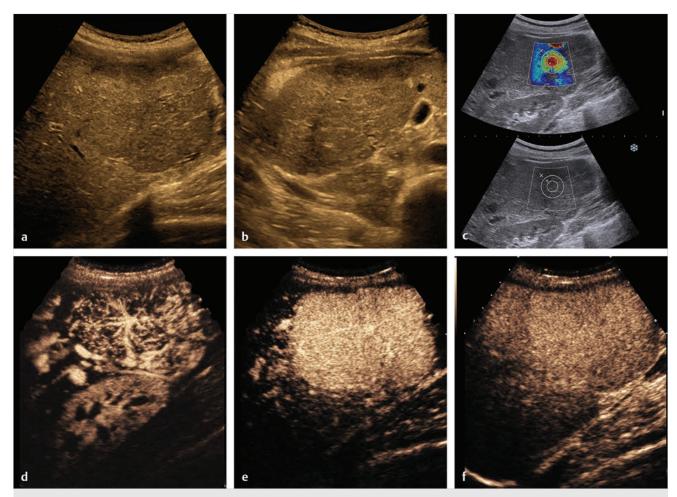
Two-dimensional shear wave elastography and contrast enhanced ultrasound (CEUS)of a focal liver mass. Patient is an asymptomatic young woman with incidental discovery of a bulbous expansive mass in the tip of the right lobe, shown in long axis (a) and cross-sectional (b) images. (c) shows a elastogram from the central portion of the mass where there is a red signal suggesting stiff tissue and likely a scar. (d, e, f) are images from CEUS that show classic features of focal nodular hyperplasia. (d) is a MIP (maximum intensity projection) image in the arterial phase showing stellate vascularity. (e) At the peak of AP (arterial phase) enhancement, there is uniform hypervascularity. (f) A delayed image at 5 minutes shows that the mass has sustained enhancement.
